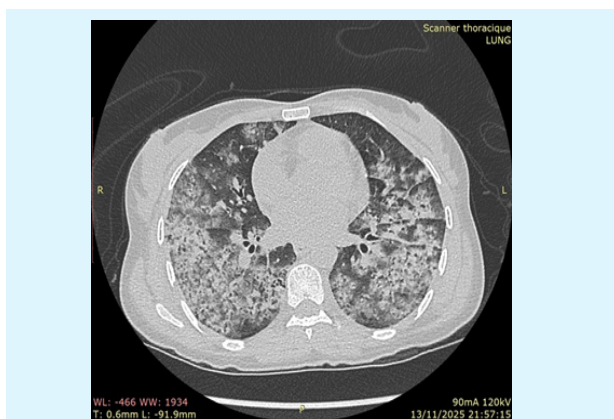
High-Resolution Computed Tomography of Thorax – Axial View
